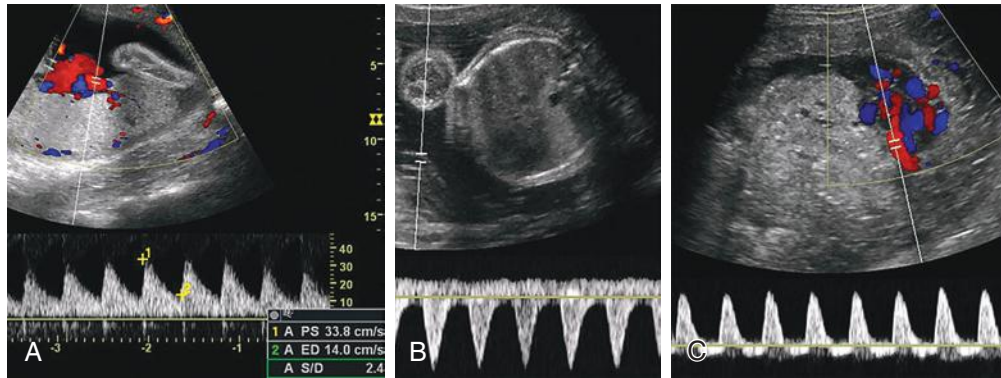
Umbilical artery Doppler velocimetry. A, Normal umbilical artery Doppler waveform with diastolic flow present. Systolic/diastolic (S/D) ratio 2.4. B, Absent diastolic flow. C, Reversed end-diastolic flow.
